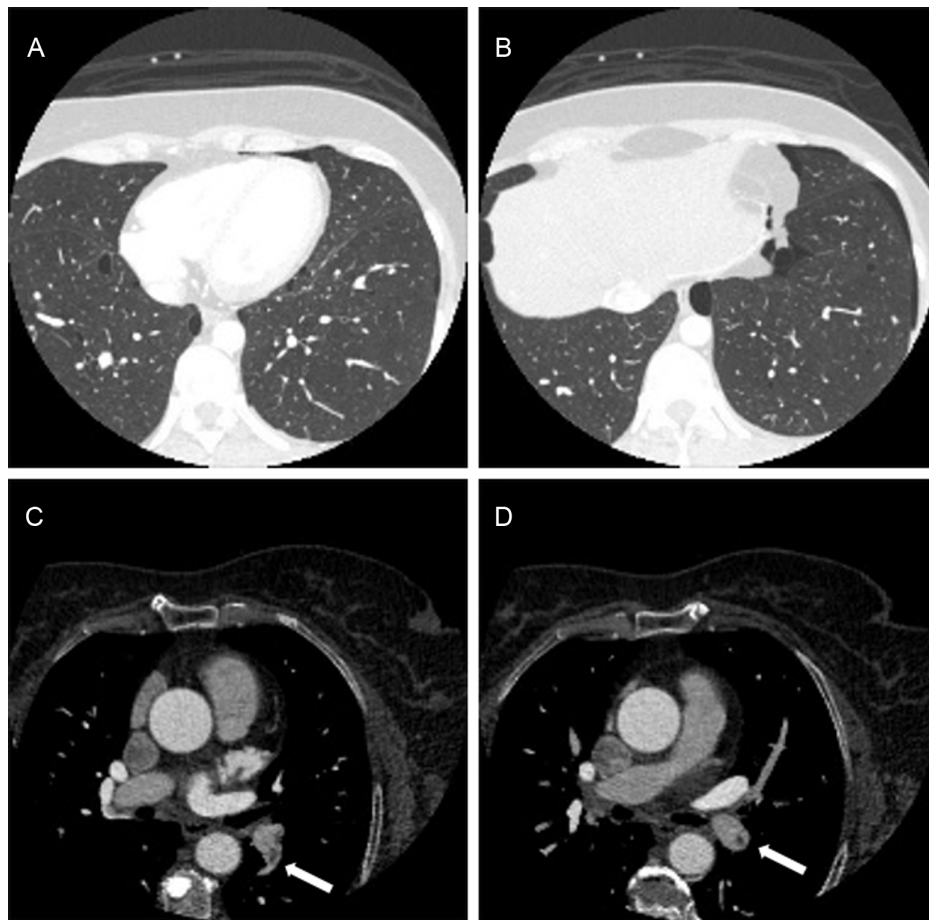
Two examples of noncardiac findings identified on axial CCTA. (A and B): Multiple cysts predominantly in the subpleural and perifissural lung with pneumothorax diagnosed as Birth-Hogg-Dube syndrome after clinical consultation. (C and D): Acute pulmonary embolism in the left lower lobe pulmonary artery (white arrow). CCTA, coronary computed tomography angiography.
